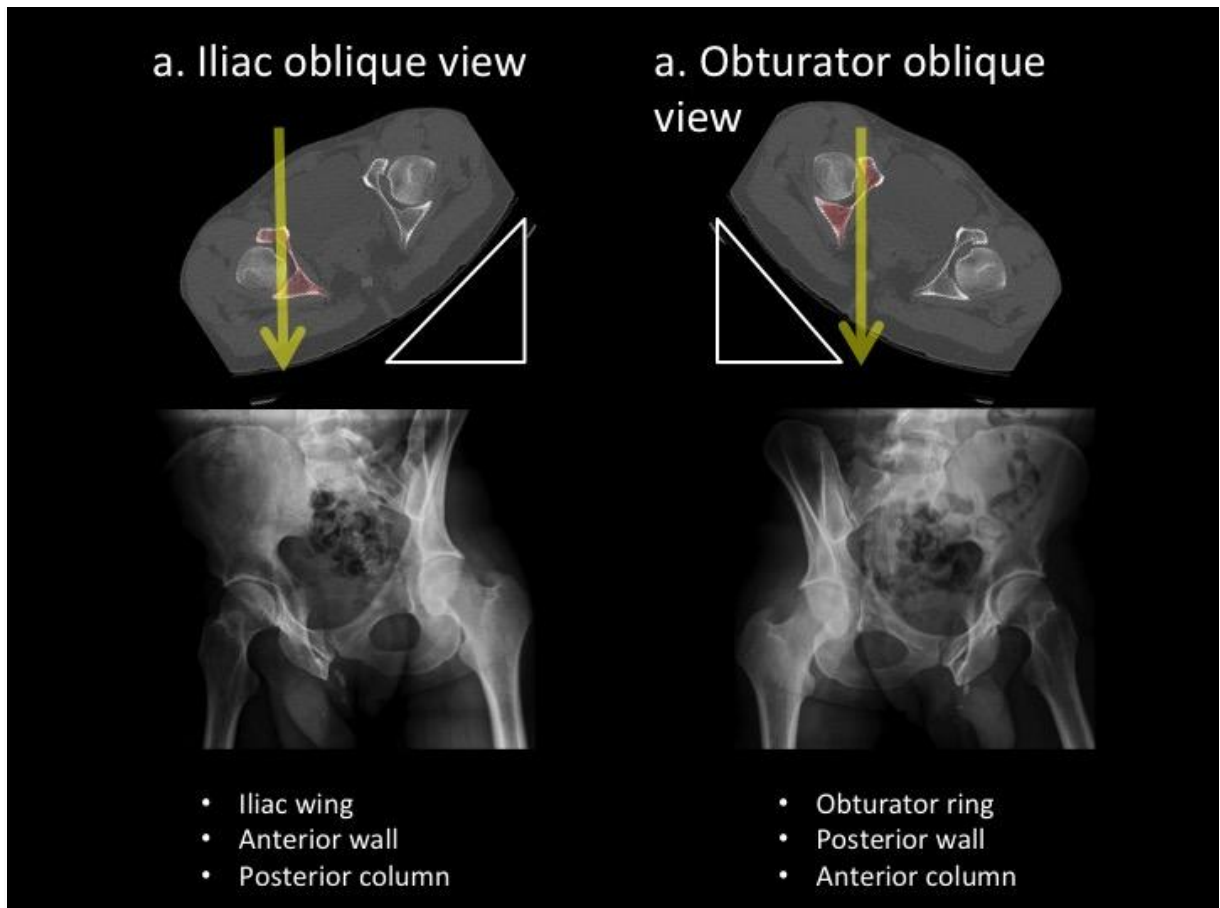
The Judet views in X-Ray radiograph and structures visualized
